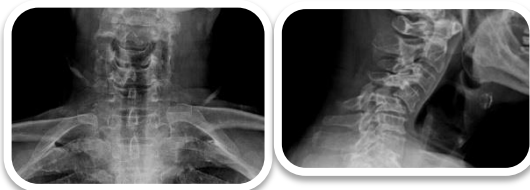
Anteroposterior (AP) and lateral cervical X-ray taken 6 months after trauma, showing severe anterolisthesis of C4 on C5
